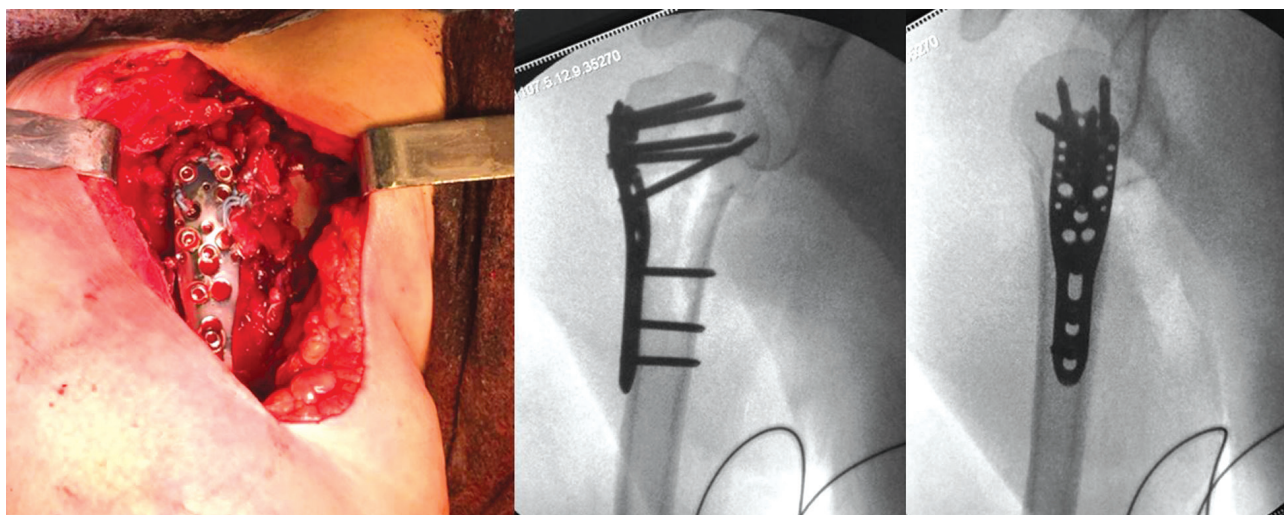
Photo and radiographs of the final fixation of the fracture
